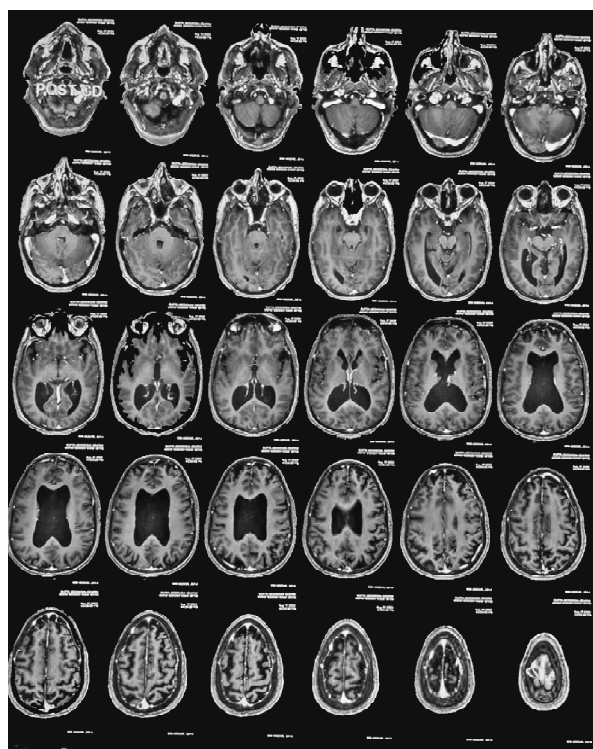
MRI Scan (Brain) showing hydrocephalus
